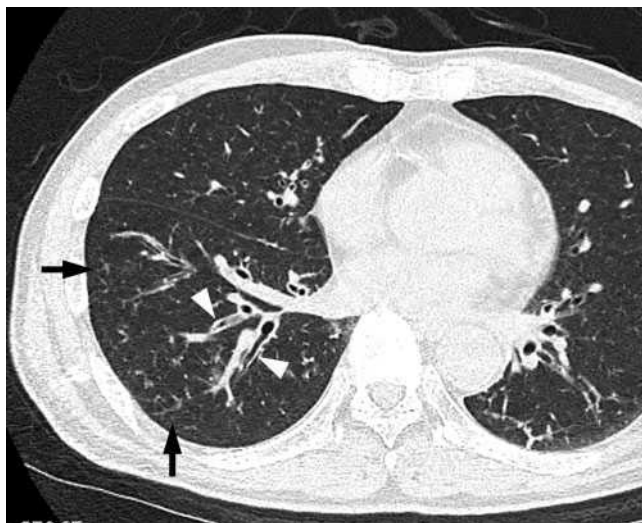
Acute pneumonia caused by *Streptococcus pneumoniae* along with concurrent methicillin-susceptible *Staphylococcus aureus* in a 67-year-old male with a smoking habit, liver disorder and lung cancer, 4 days after the onset of a cough with sputum and fever. Transverse CT image of the right lower lobe shows centrilobular nodules (arrows) and bronchial wall thickening (arrowheads).
